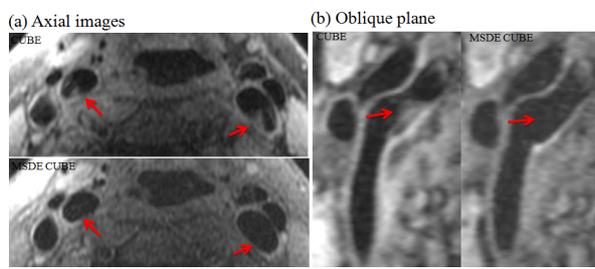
CUBE MRI of a normal volunteer's carotid. (a) CUBE (top) and iMSDE CUBE (bottom) images in the axial plane; (b) Reformatted CUBE (left) and iMSDE CUBE (right) images in an oblique plane. Note the suppression of residual blood signal on the iMSDE preparation (arrowed).
